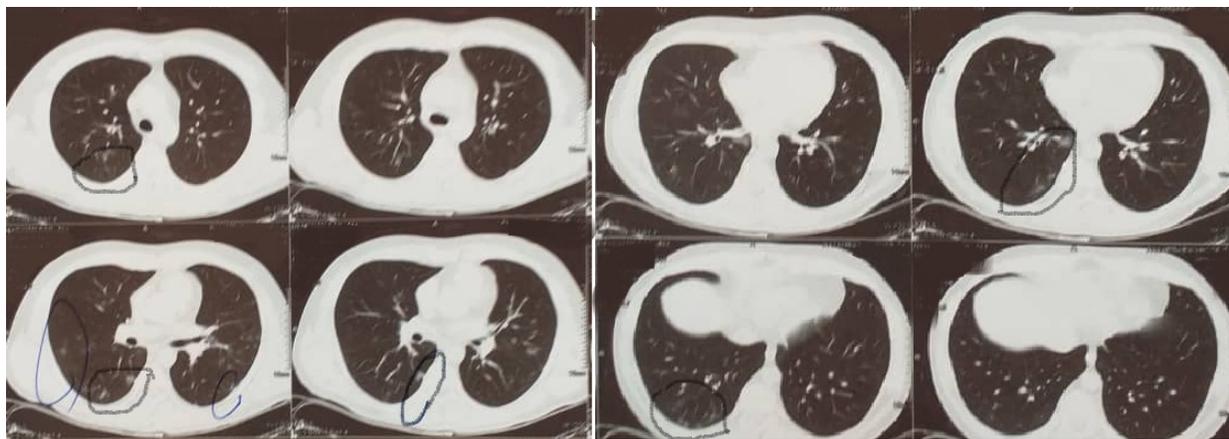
Chest CT scan of case 5 shows patchy peripheral opacities (circles) in both lungs more severe in right lung in favor of COVID-19 diagnosis
